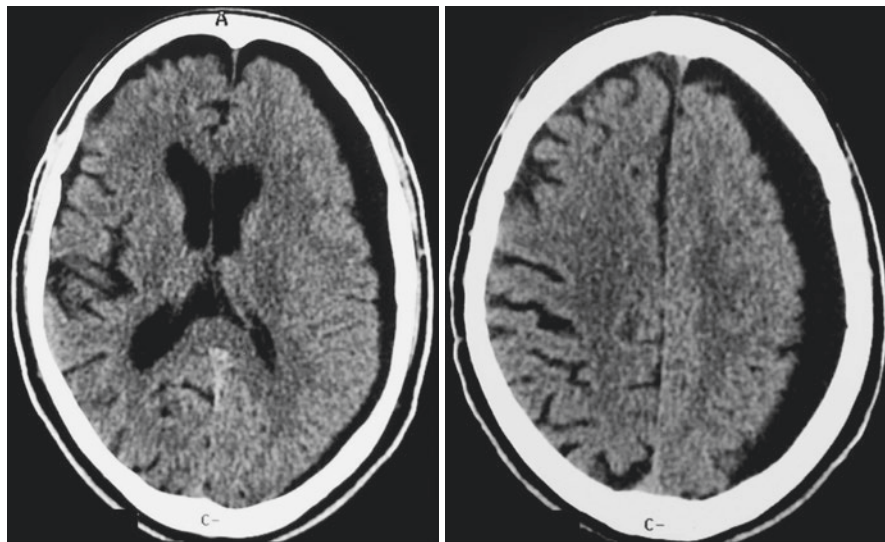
Axial cranial CT-scan showing a left hemispheric subdural hygroma with parenchymal brain compression
